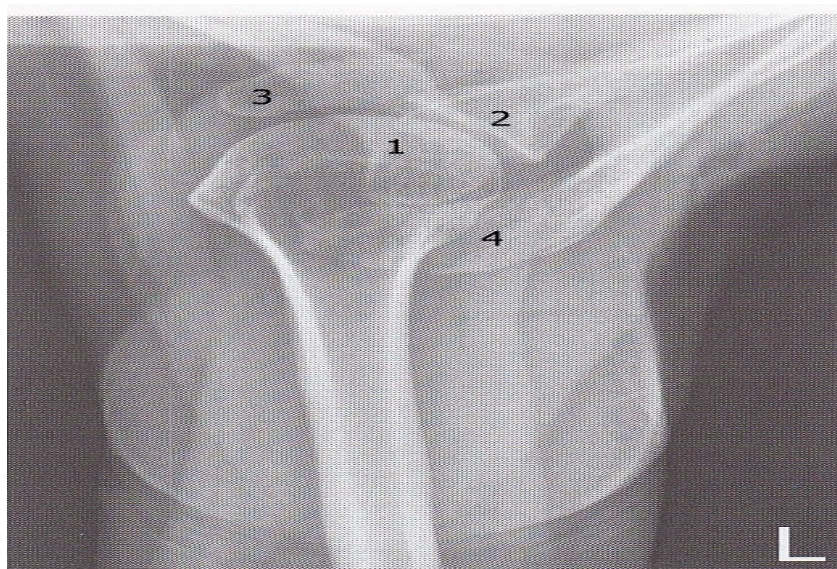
A Superior-inferior axial radiograph of a normal left shoulder joint showing the humeral head (1), the glenoid cavity (2), the coracoid process (3) and the acromial process (4) (Whitley et al., 2005).
